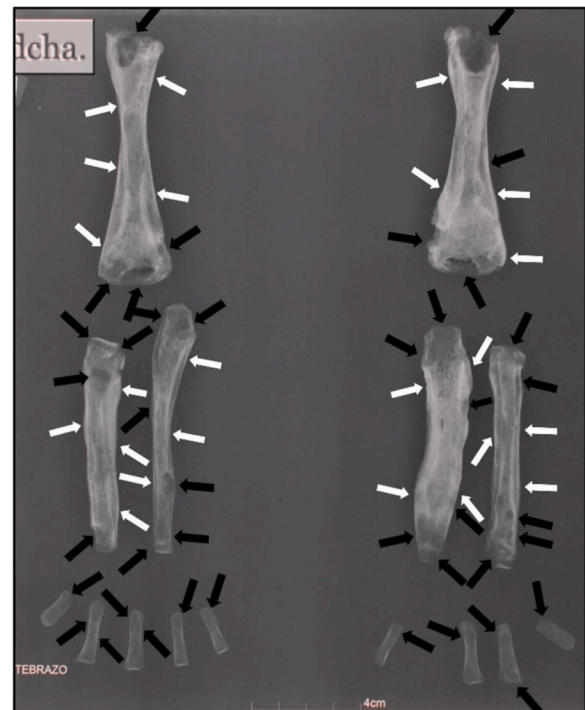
Radiograph of the right and left arm bones of Individual IG-493, anterior view. The black arrows indicate osteolysis, the white arrows indicate areas of marked cortical thickening.
